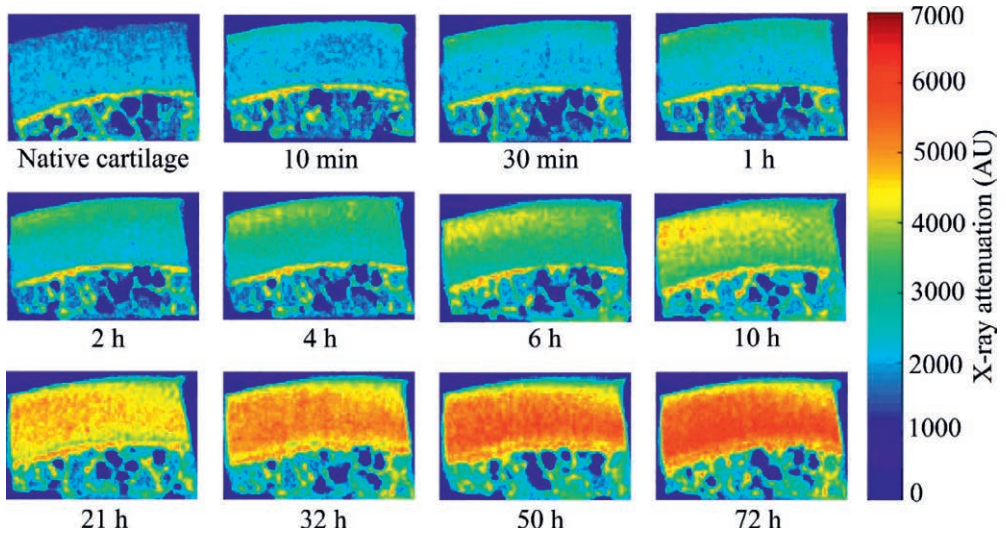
Human osteochondral plug (frontal plane) imaged with a high-resolution microcomputed tomography scanner (tube voltage = 50 kVp) before and after immersion in a contrast agent bath (a mixture of CA4+ and gadoteridol) for 10 min, 30 min, 1, 2, 4, 6, 10, 21, 32, 50, and 72 h. The higher X-ray attenuation in the cartilage results from the increase in immersion time.
